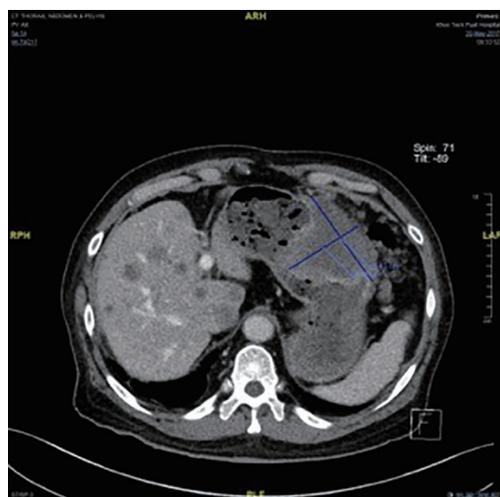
CT scan of the thorax, abdomen and pelvis showing advanced primary gastric GIST with peritoneal deposits and liver metastases. CT, computed tomography; GIST, gastrointestinal stromal tumor.
